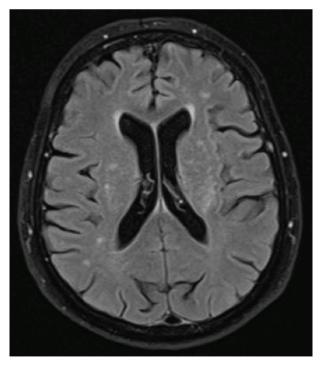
Magnetic resonance imaging, T2 sequence: supratentorial region, hyperintense punctiform lesions.
